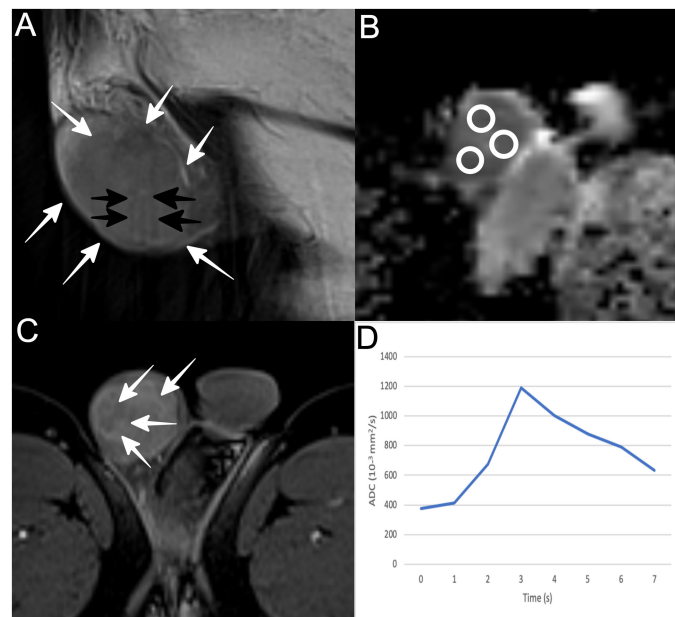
Right testicular seminoma in a 23-year-old man. (A) Sagittal T2-weighted image shows hypointense right testicular mass (white arrows). Tumor septa are also seen as hypointense bands (black arrows). (B) Axial ADC map ($b = 800 \text{ s/mm}^2$) shows tumor's restricted diffusion. The mean ADC values of tumor (circular ROIs) were $0.49 \times 10^{-3} \text{ mm}^2/\text{s}$. (C) Axial DCE image at early phase (180 seconds) shows heterogeneous tumor enhancement. Septal enhancement (arrows) more than the remaining tumoral tissue. (D) TSI curve shows early tumor enhancement, followed by gradual washout in the delayed phase (type III).
